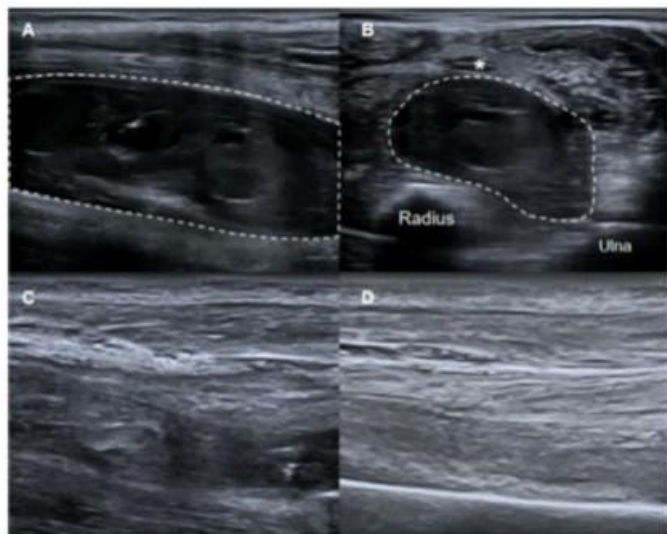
Ultrasound examination revealed a polycystic hematoma in the flexor of the forearm (Long Axis section of hematoma, A). The hematoma was located between median nerve (*), radius and ulna (Short Axis section of hematoma, B). Three days after drainage and urokinase lavage, ultrasonography showed that the hematoma had nearly disappeared (C). Hematoma did not recur at the 4-month follow-up after treatment (D).
